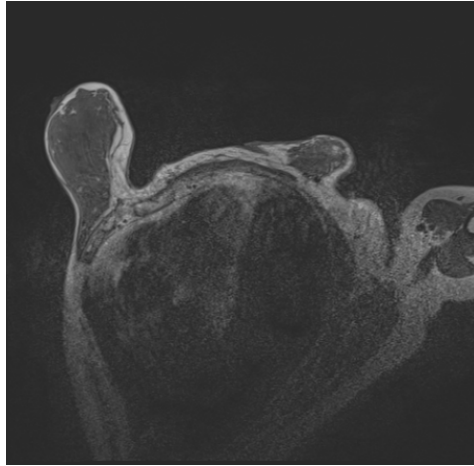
Prior DCE-MRI study of a patient with post-polio scoliosis and thorax deformation.
